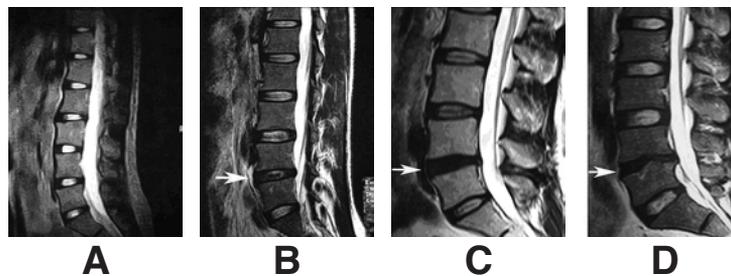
Magnetic resonance imaging showing normal and degenerate discs. (A) Normal lumbar intervertebral disc, with a bright, hyperintense white signal intensity (L4/5). (B) Early stages of a degenerating disc, with an intermediate gray signal intensity (L4/5 disc, arrow). (C) Later stages of a degenerating disc, with a hypointense dark gray signal intensity (L4/5 disc, arrow). (D) Advanced stage of degenerating disc, with a hypointense black signal intensity and a narrowing disc space (L4/5 disc, arrow).
